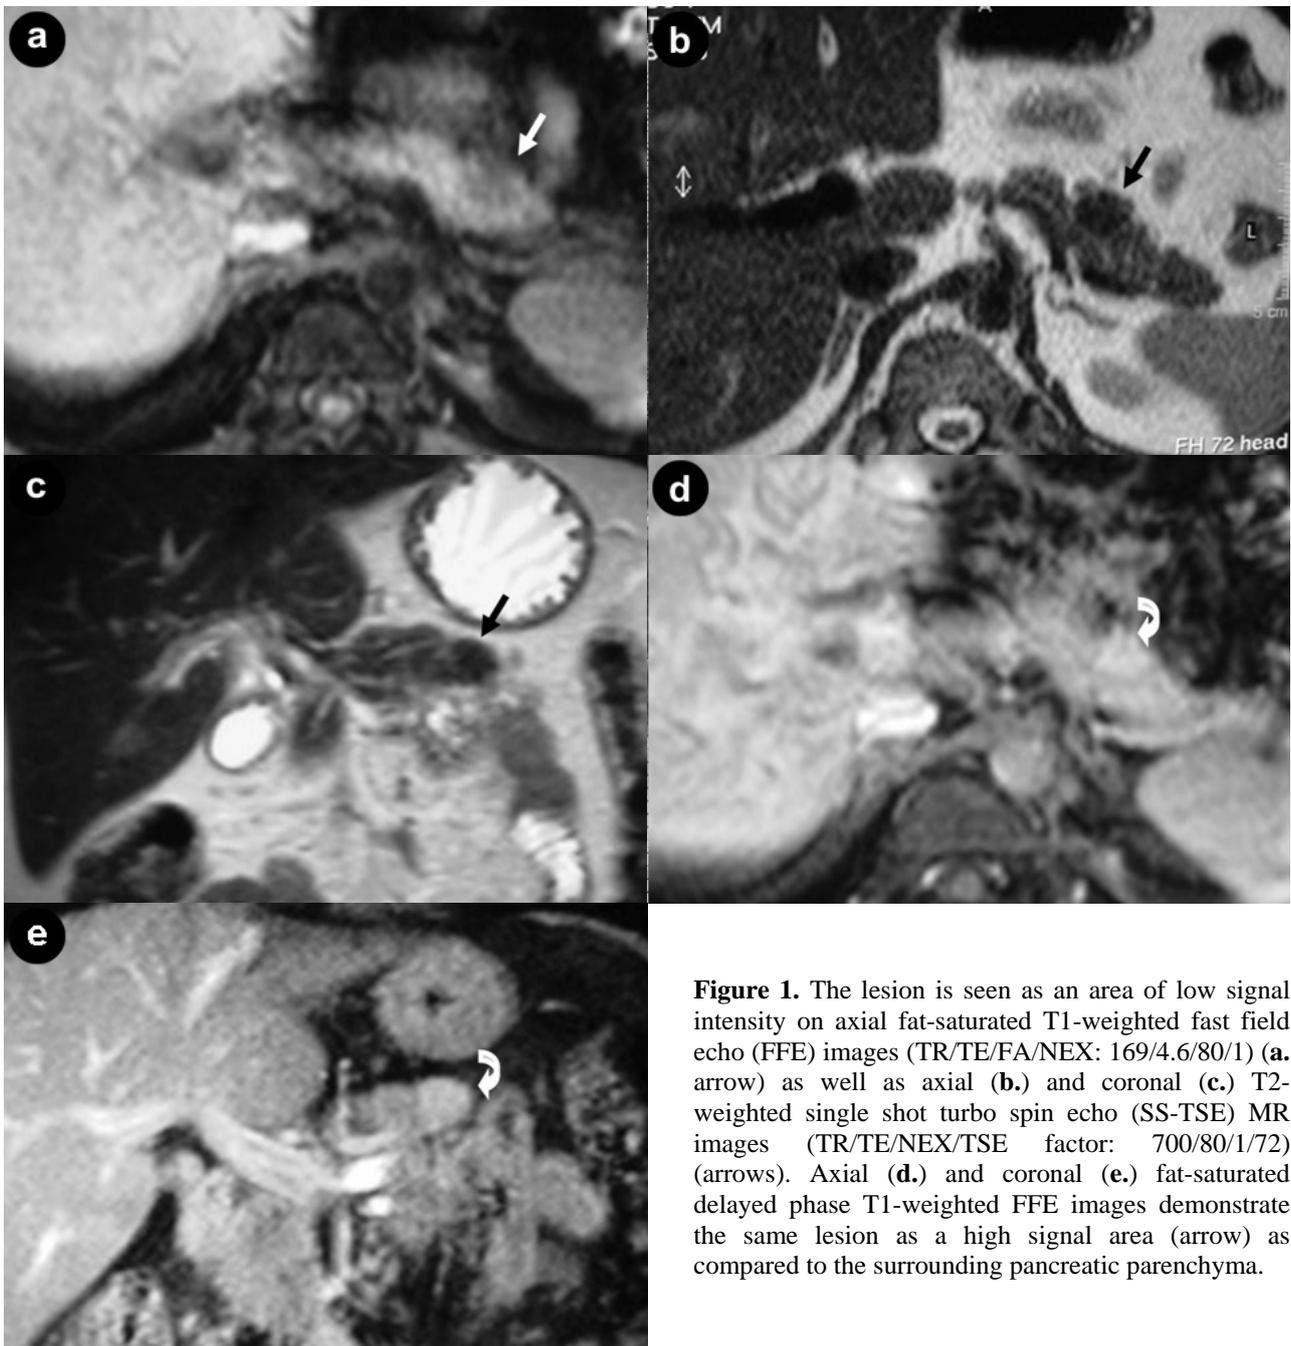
The lesion is seen as an area of low signal intensity on axial fat-saturated T1-weighted fast field echo (FFE) images (TR/TE/FA/NEX: 169/4.6/80/1) (a. arrow) as well as axial (b.) and coronal (c.) T2-weighted single shot turbo spin echo (SS-TSE) MR images (TR/TE/NEX/TSE factor: 700/80/1/72) (arrows). Axial (d.) and coronal (e.) fat-saturated delayed phase T1-weighted FFE images demonstrate the same lesion as a high signal area (arrow) as compared to the surrounding pancreatic parenchyma.
